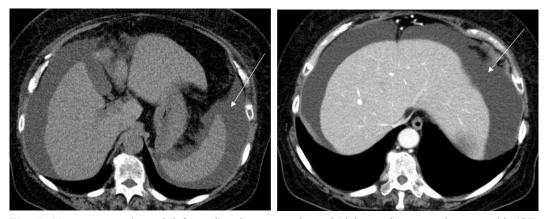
Non-contrast-enhanced (left panel) and contrast-enhanced (right panel) computed tomographic (CT) scans of the abdomen showing marked amount of abdominal ascites (arrows) with fluid surrounding the spleen and the liver in a patient with SLE.
